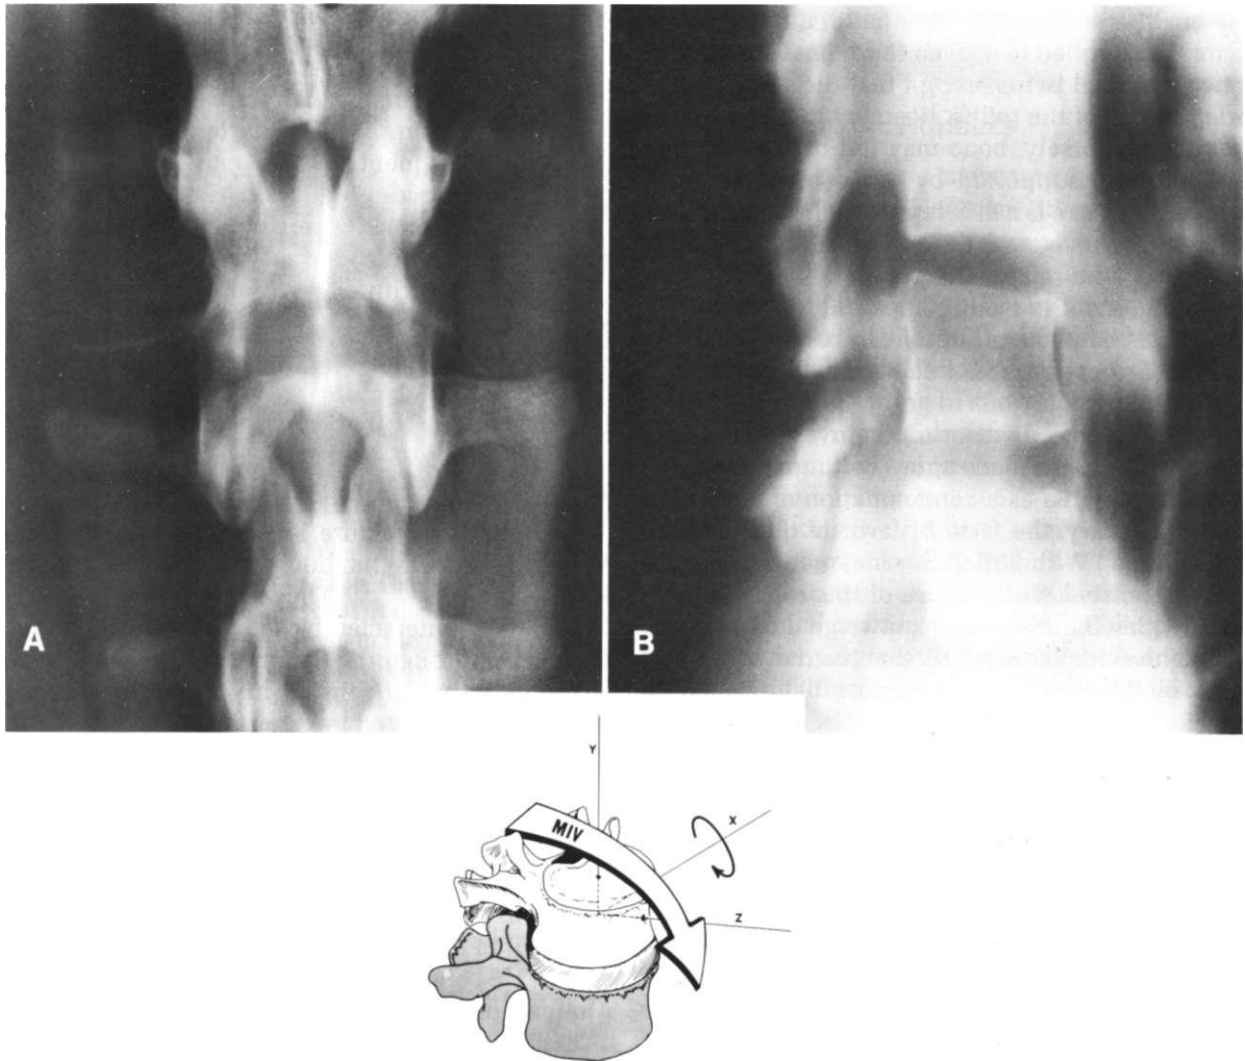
Radiographs of a 16-year-old girl who was riding in the front passenger seat of an automobile when it suddenly decelerated as a result of an impact with a telephone pole. (A) Lateral laminagram shows moderate compression fracture of the most anterior portion of the bodies of L3 and L4, with a horizontal fracture through the posterior elements of L3. (B) An anteroposterior view of the fractures of the posterior elements. Note how the clean horizontal slice cuts through the spinous process, the lamina, the pedicle, and actually the right transverse process. The MIV is a positive torque about the x-axis. There is compressive loading anterior to the axis of rotation and tensile loading posterior to it. In this particular case, the axis of rotation is somewhere in the central portion of L3. (Radiographs courtesy of Dr. E. M. Rhodes)
